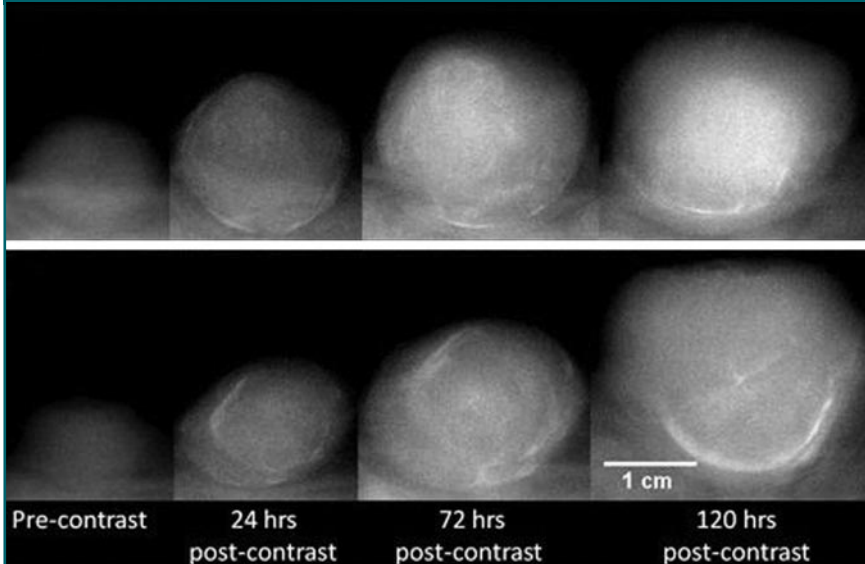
X-ray images of two tumors before and after injection of probe at dose of 455 mg of iodine per kilogram. Top: Tumor A. Bottom: Tumor B. Signal enhancement, in terms of gray levels, of tumor A is higher than that of tumor B by 40 and 70 digital units at 72 and 120 hours after injection, respectively; difference is clearly visible.
